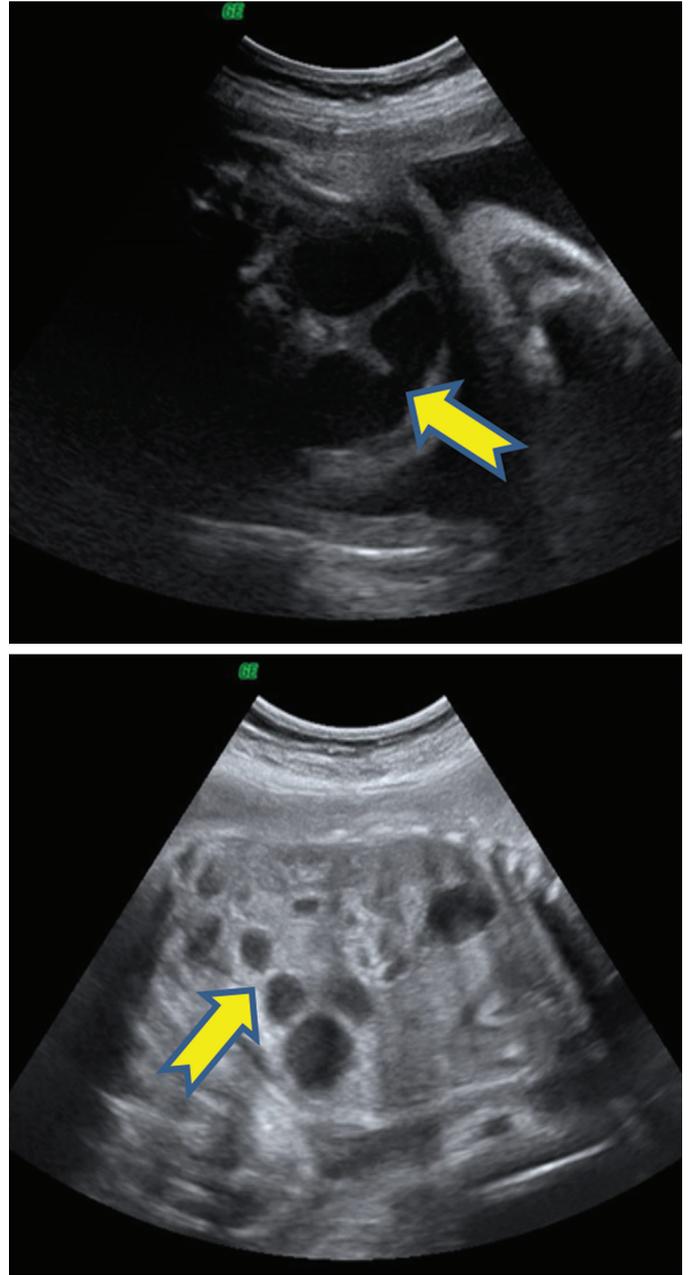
At the time of the 28th gestational weeks, we observed dilated bowel loops with the widest diameter of 20 mm, containing intraabdominal calcified areas on ultrasonographic examination
